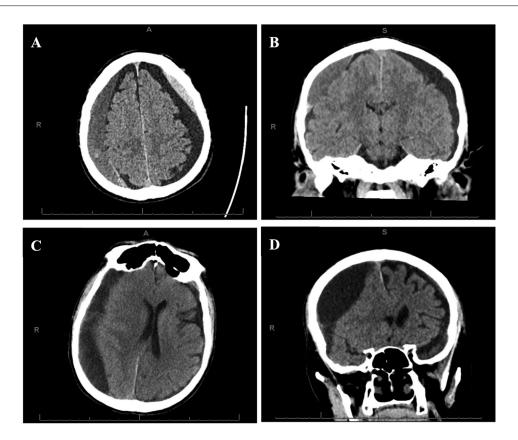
Head Computed Tomography (CT) on initial and subsequent emergency department presentation. On initial presentation to the ED after sustaining a fall from standing: axial (A) and coronal (B) CT showed bilateral mixed density chronic subdural hematomas (cSDH) with no midline shift. Upon re-presenting to the emergency department a month later after sustaining another fall: axial (C) and coronal (D) CT showed enlargement of right-sided cSDH measuring 3 cm with 1 cm of midline shift.
